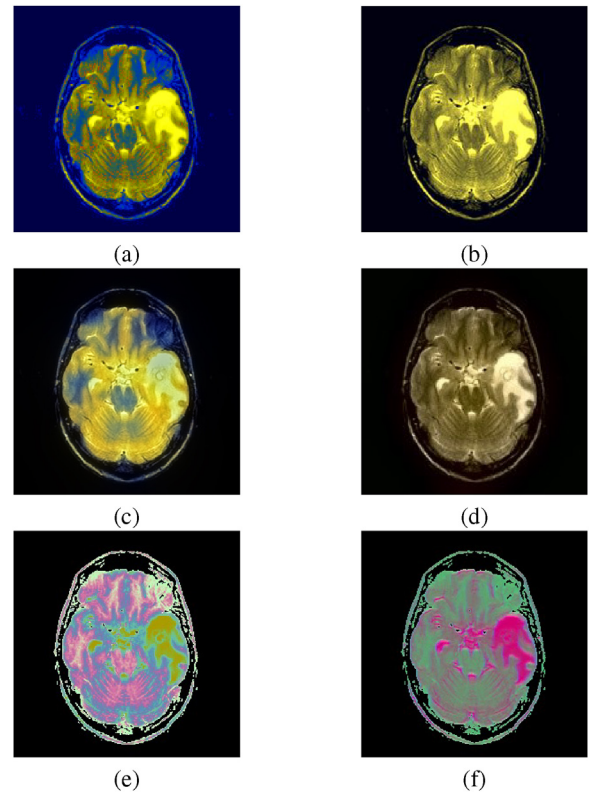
Color perception of MRI images. (a) TCGI [3], (b) CTCCS [5], (c) ACGCDT [6], (d) ICTED [7], (e) CPMI-DPHC(LE), (f) CPMI-DPHC(MDS). (For interpretation of the references to color in this figure legend, the reader is referred to the web version of this article.)
